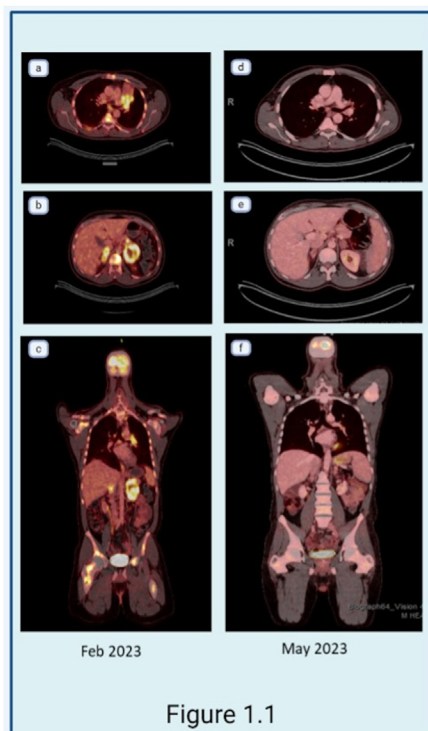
Response to LO. LO, lurbinectedin plus osimertinib. Figure 1.1. (A-C) PET-CT scan showing disease progression after carboplatin/etoposide/atezolizumab with increasing metabolic activity of thoracic lymph nodes, adrenal gland lesions, and lesion in the left hepatic lobe with development of additional lesions in the right hepatic lobe, lesion in the pancreatic body/tail, and innumerable additional osseous lesion. (D-F) Significant improvement in the progressive disease after two cycles of LO. LO, lurbinectedin plus osimertinib; PET-CT, positron emission tomography-computed tomography. Figure 1.2. (A-C) A CT scan shows disease progression after carboplatin/etoposide/atezolizumab with new pulmonary nodules and a mass centered in the right abdominal wall indenting the right lobe of the liver. (C-F) A CT scan shows improvement in peri-hepatic metastatic disease but a progression of metastatic disease in the thorax. CT, computed tomography. Figure 1.3. (A-C) PET-CT scan shows progressive disease on carboplatin/etoposide/atezolizumab with osseous and pulmonary lesions. (D-F) Shows disease progression on LO with worsening osseous and pulmonary lesions. LO, lurbinectedin plus osimertinib; PET-CT, positron emission tomography-computed tomography.
